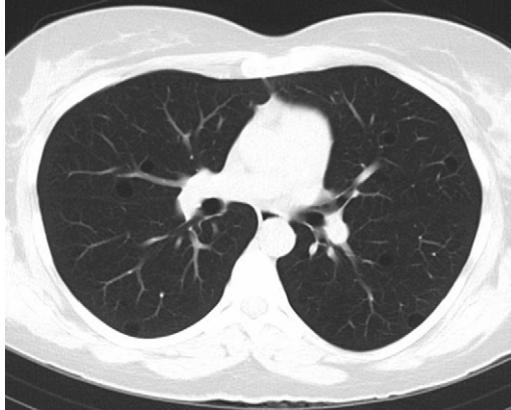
HRCT image of a patient with primary SjS. This patient had the incidental finding of subclinical cystic lung disease most suggestive lymphocytic interstitial pneumonia.
